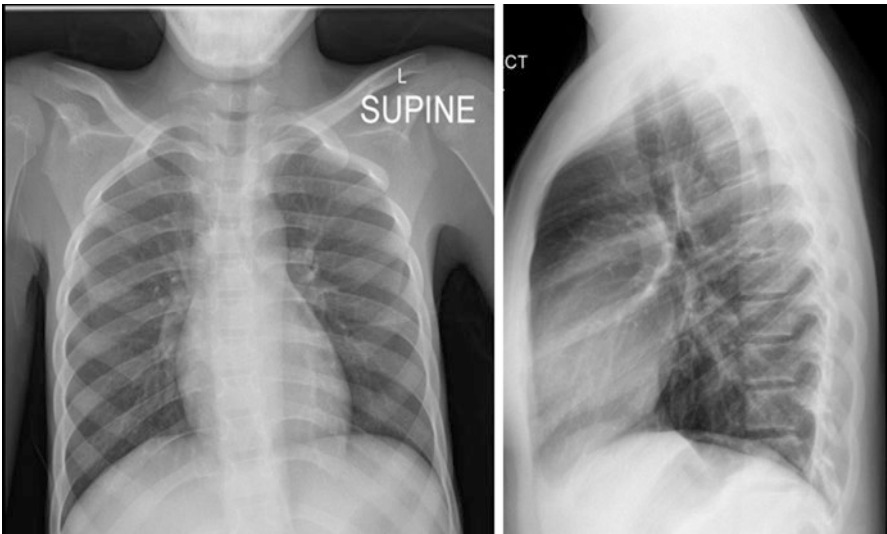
Chest X-ray: AP and lateral
